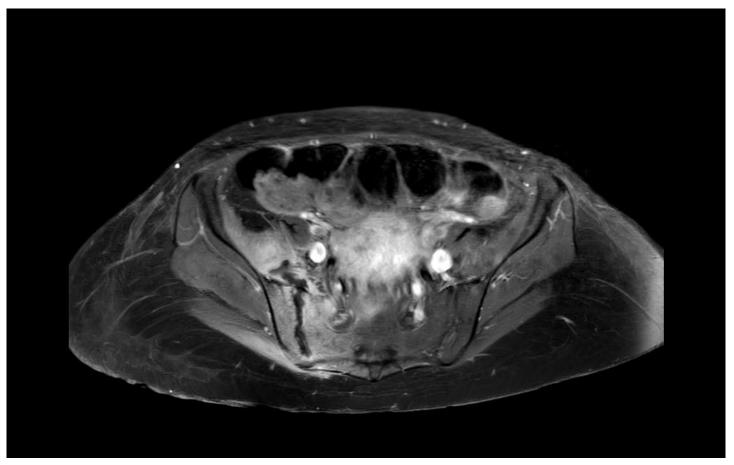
Cross-sectional T1 weighted MR imaging showing an abscess underneath the iliacus muscle in frontal to the SI joint
